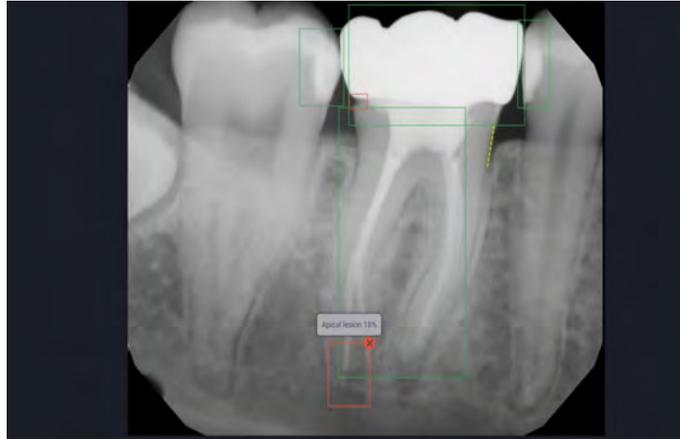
Screen Shot of a Periapical Radiograph that Includes an Endodontically Treated Tooth and has been Analyzed by their AI Algorithms.
